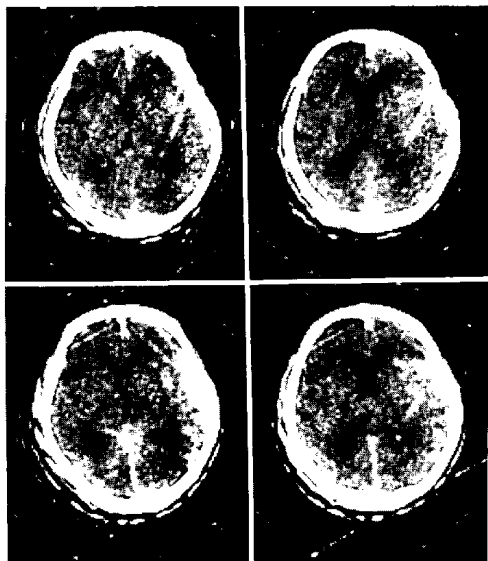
Cerebral contusion. 61-year-old female. A patchy high density area can be recognized in the right frontotemporal area (upper), which is enhanced by intravenous contrast material injection (lower). CT was taken about 2 hours after trauma.
